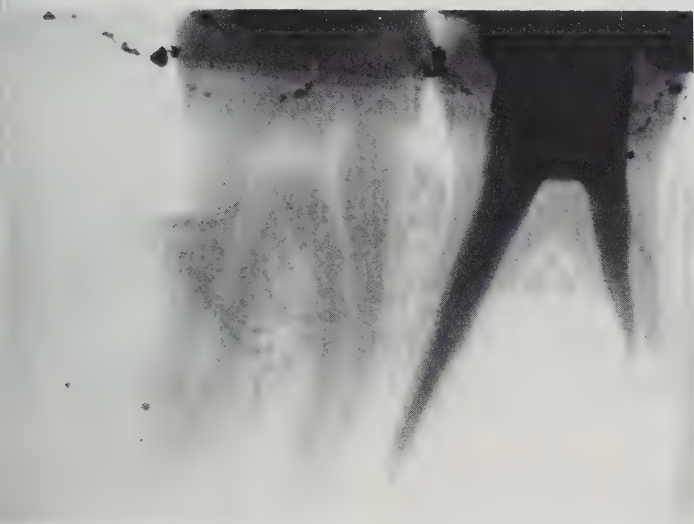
Periapical radiograph taken on January 1, 1973 following endodontic treatment of left mandibular first molar.
